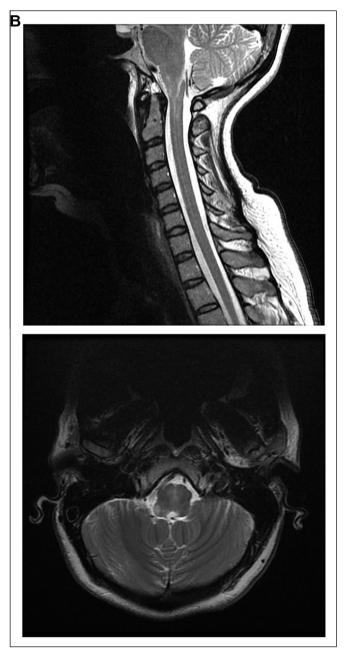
Sagittal and axial T2-weighted MRI obtained after one year of therapy, showing resolving lesion at the cervicomedullary junction and upper cervical cord.
